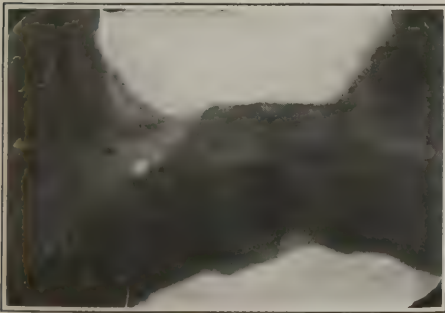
Radiograph showing consolidation of bone beneath splint. September 1, 1919, splint removed.
